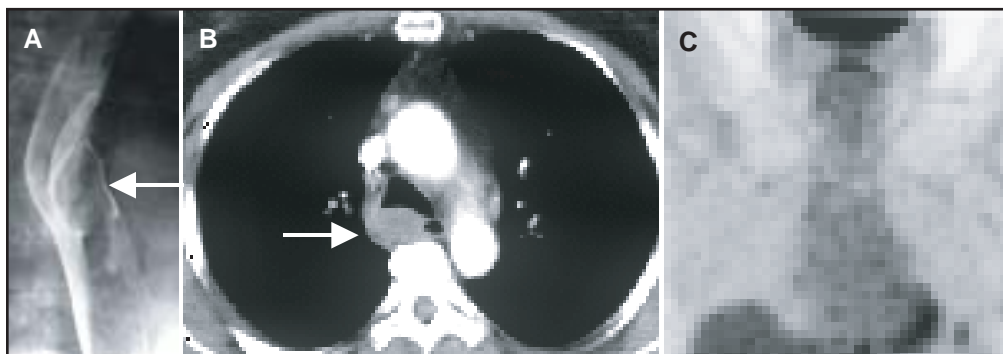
Esophageal GIST. (A) Air-contrast esophagram shows an intramural lesion (arrow). (B) CT demonstrates an exophytic, well-defined esophageal mass with minimal contrast enhancement (arrow). (C) Coronal PET scan demonstrates no uptake of [¹⁸F]FDG within the mass.
